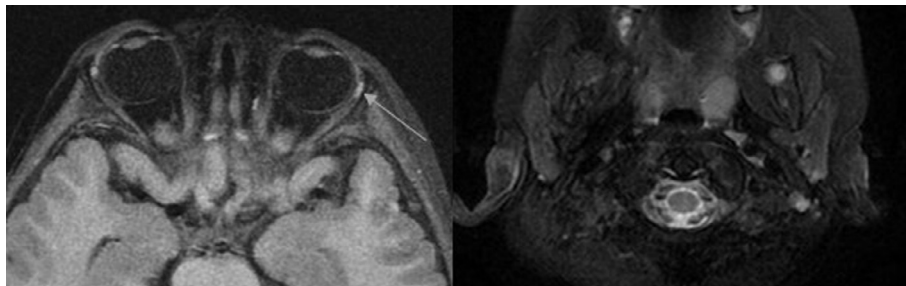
Case 1 - MRI showing non-contrast axial T1 WI and Axial T2 WI with fat suppression with the absence of both lacrimal glands with empty lacrimal fossa (white arrow) and normal appearing parotid gland.
